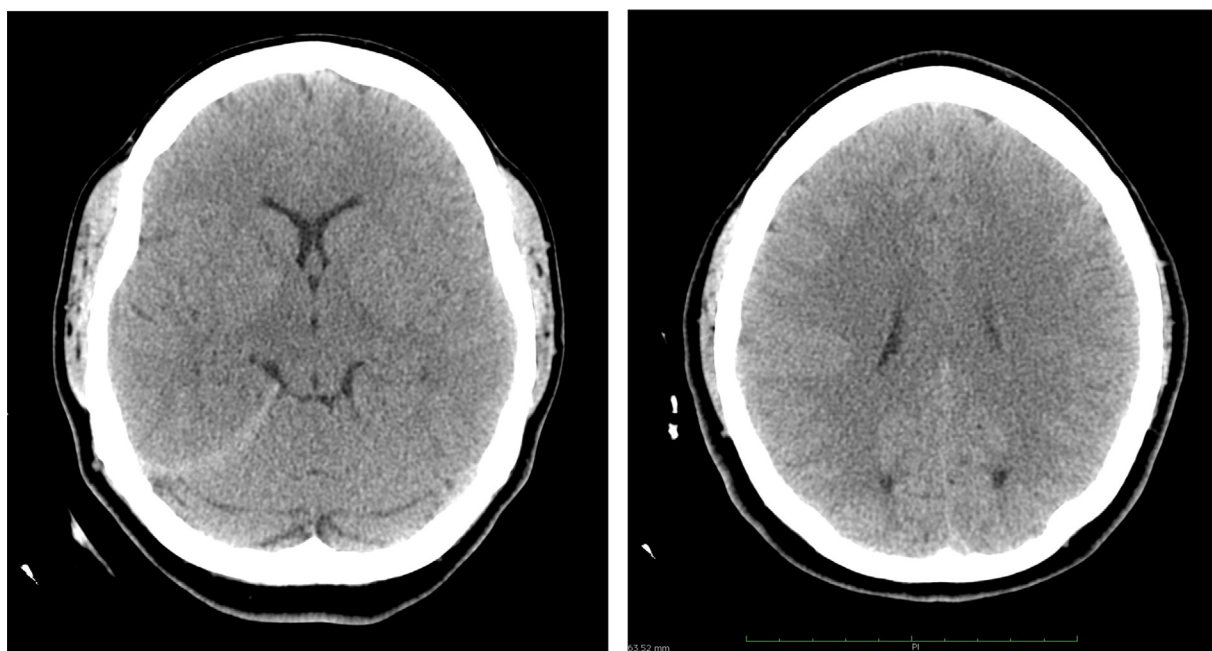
Axial non-contrast CT demonstrates brain without focal lesions and with no signs of intracranial hemorrhage. However, hematoma of soft tissues of left parietal area is present.
